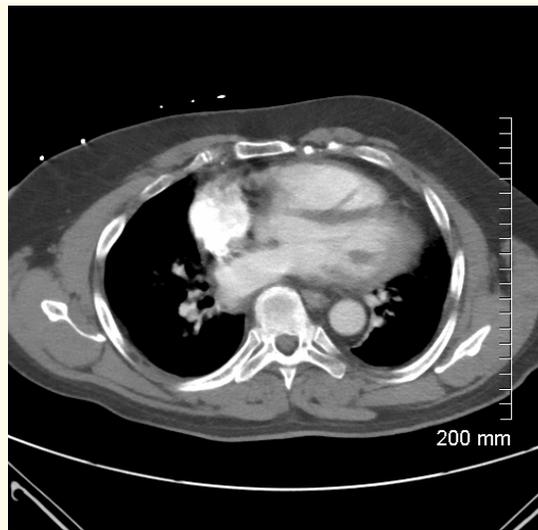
CT scan of chest showing compression of left atrium by the thoracic vertebra.
